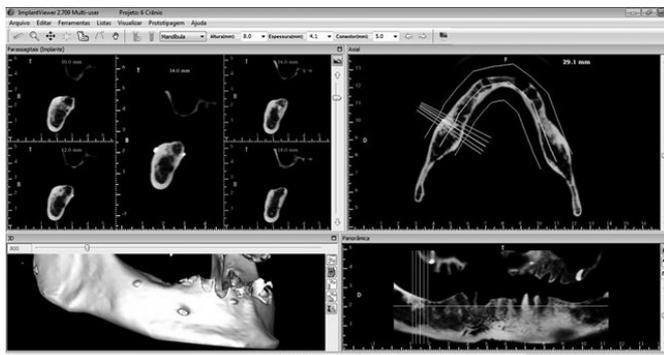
Screen view of the CT imaging software used to perform CBCT measurements.
